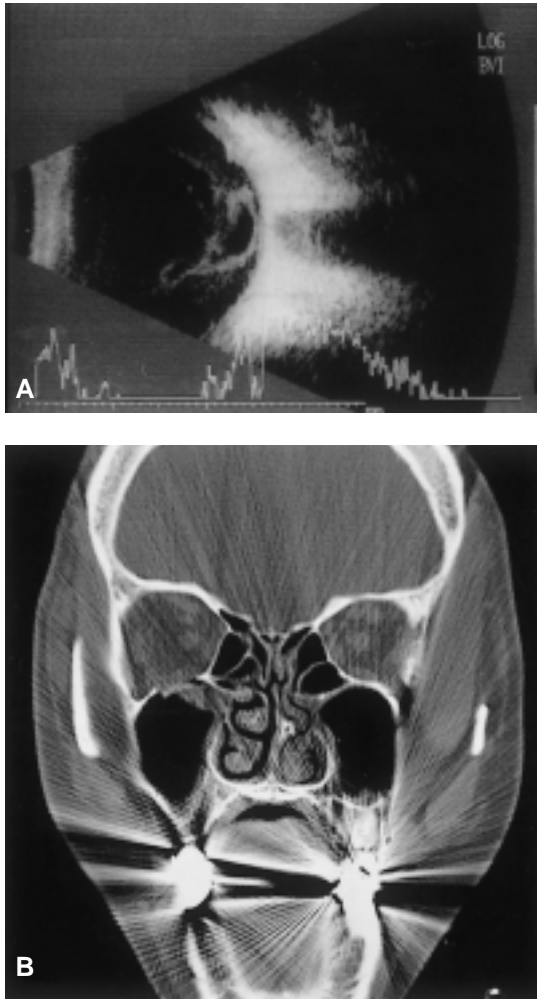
A. B-scan ultrasonogram showing vitreous hemorrhage without retinal detachment. B. Coronal CT scan of a right orbital floor blow-out fracture.
